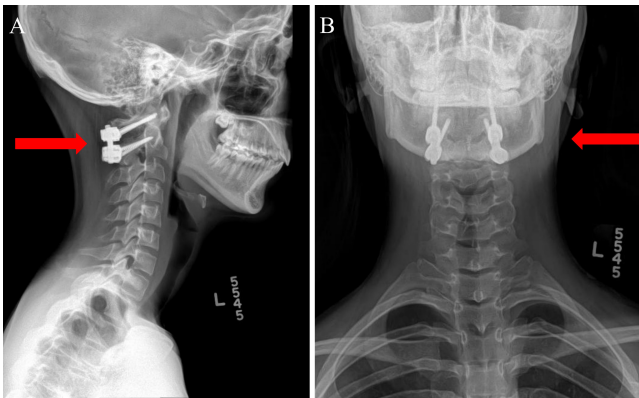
Six-month follow-up lateral (A) and anteroposterior (B) radiographs of the cervical spine, showing C1 laminectomy and posterior fusion of C1–2 with stable hardware alignment (red arrows). No paravertebral lucency is observed, cervical lordosis remains straightened, and the previously noted C1–2 widening has been corrected.
